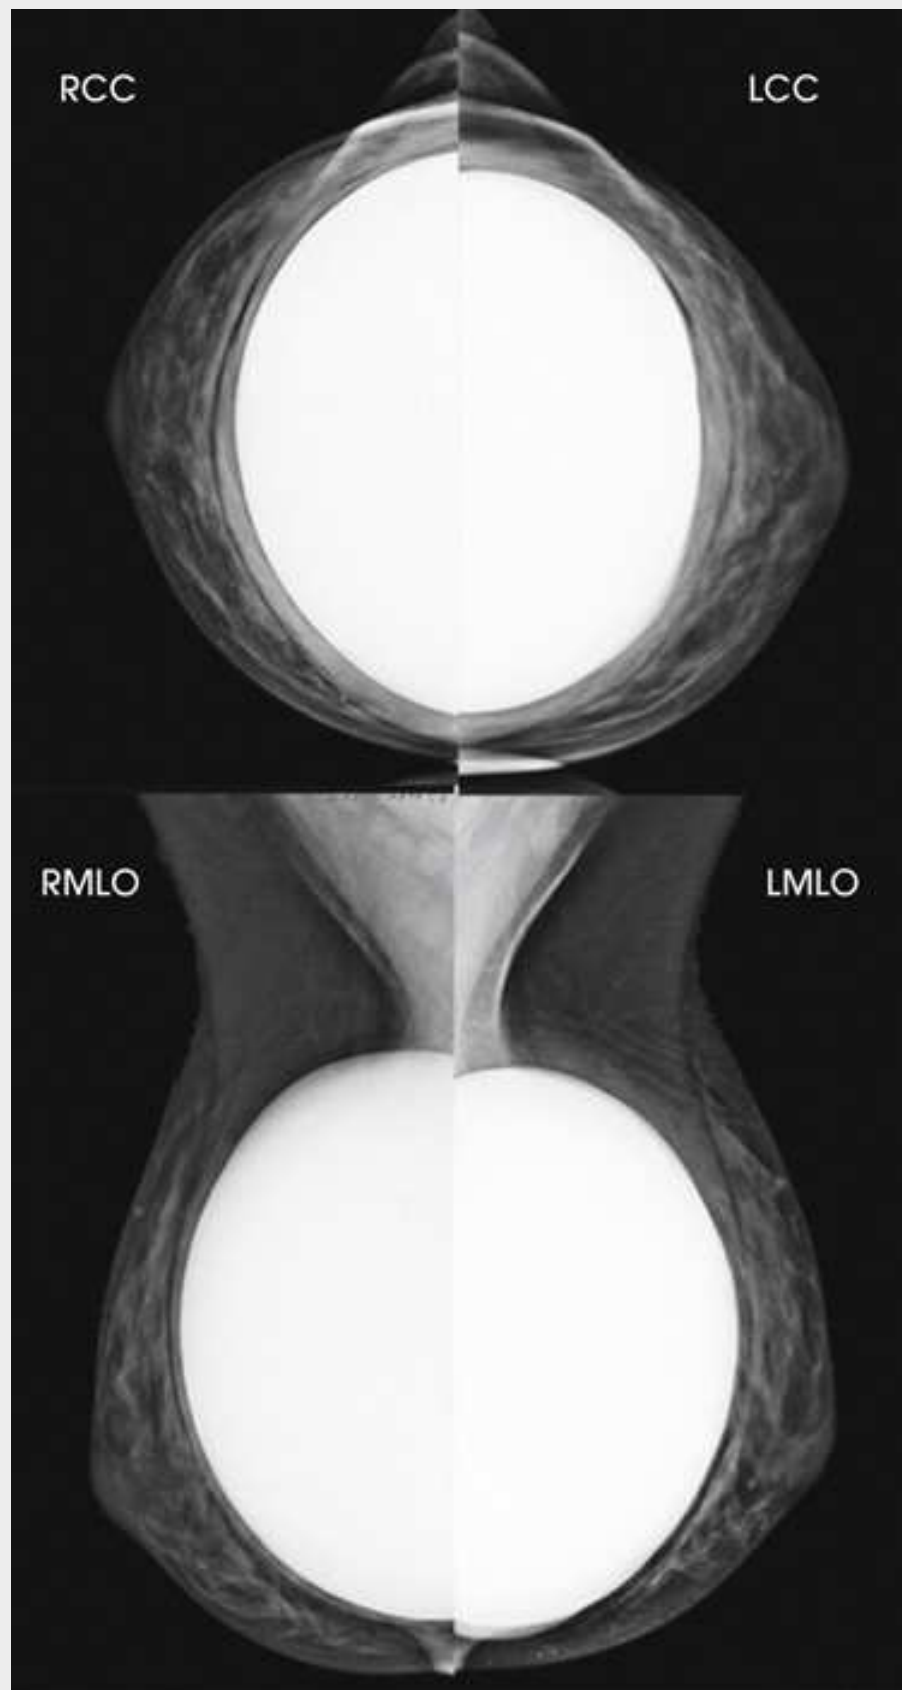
Bilateral, four-image CC and MLO examination of augmented breasts. Implants have been surgically placed behind the pectoral muscle. Additional radiographs should be obtained using the Eklund (ID) technique to complete the eight-radiograph study (see Fig. 18.35).
